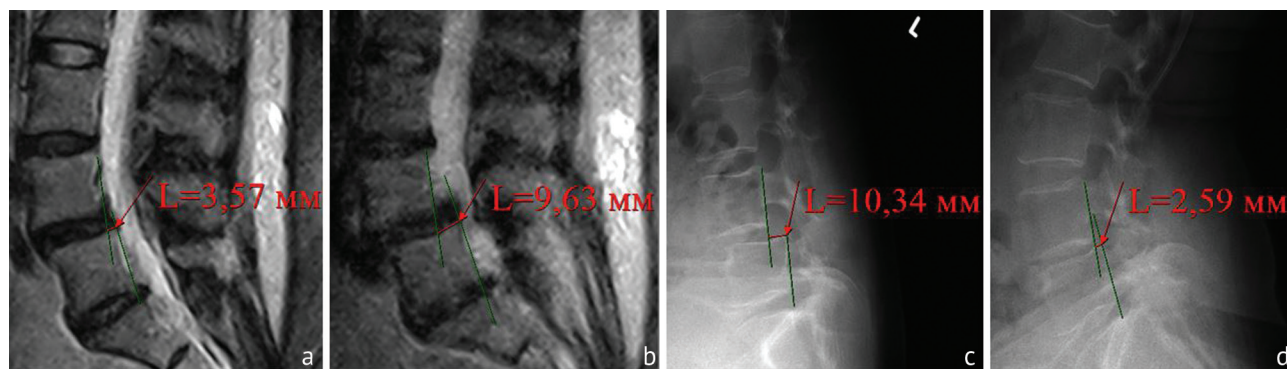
MRI scans (T2-WI) of the lumbar spine in the sagittal plane: *a* – supine position; *b* – upright position. Radiographs of the lumbar spine in the lateral projection: *c* – flexion; *d* – extension position. The magnitude of the displacement of the vertebrae in functional load test, obtained by X-ray and MRI, is comparable
